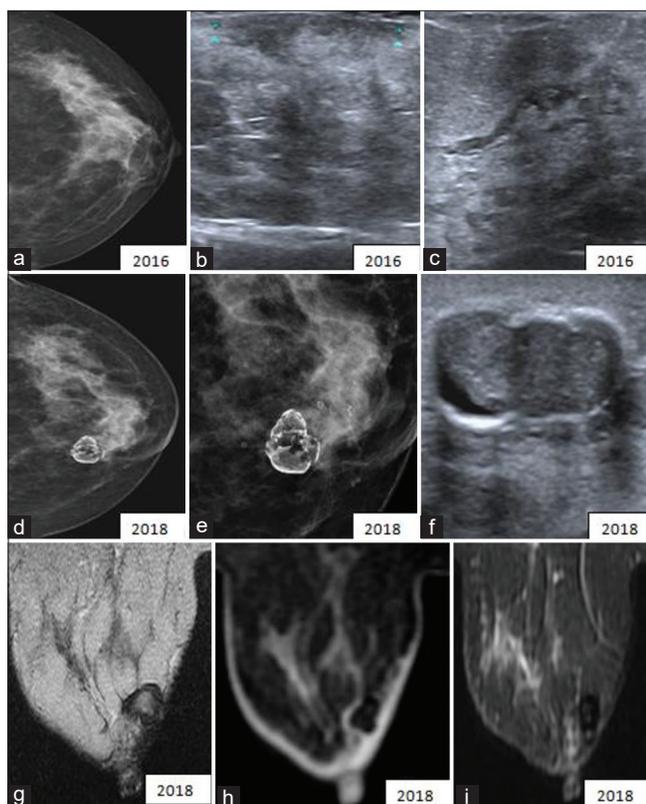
A 43-year-old female with a history of surgery for malignancy in 2015. November 2016 imaging for a routine checkup – (a) X-ray mammogram CC view of the left breast appears normal. (b and c) Ultrasound image shows ill-defined areas of heterogeneity at the operative site corresponding to post-operative inflammatory changes. November 2018 imaging for a routine checkup – X-ray Mammogram of the left breast (d) CC view and (e) zoomed-in view shows a circumscribed radiolucent mass with rim calcification suggestive of fat necrosis. Few other small oil cysts with rim calcification are noted adjacent to the larger lesion. (f) Ultrasound image shows an oval parallel oriented circumscribed hypodense mass with peripheral calcification in the mass and combined posterior features. (g) Axial sections of T2 weighted magnetic resonance imaging (MRI) shows a circumscribed isointense mass compared to adjacent parenchyma with peripheral hypointense rim. (h) Axial T2 FS images show hypointense mass, with fat being suppressed within the mass. (i) Axial contrast-enhanced MRI shows a non-enhancing mass
